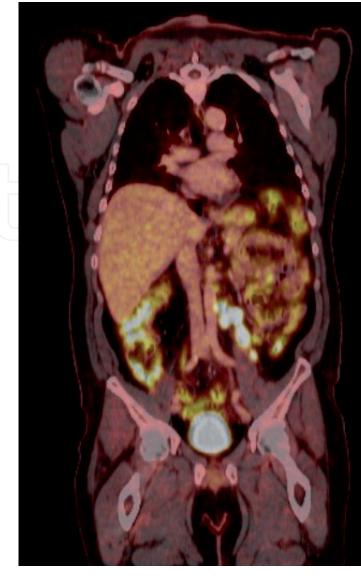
PET/CT in a patient diagnosed with a PTL (diffuse large B-cell lymphoma). Numerous hypermetabolic left paraaortic lymphadenopathy (16 mm and SUVmax: 18), located in the anterior aspect of the psoas.*
